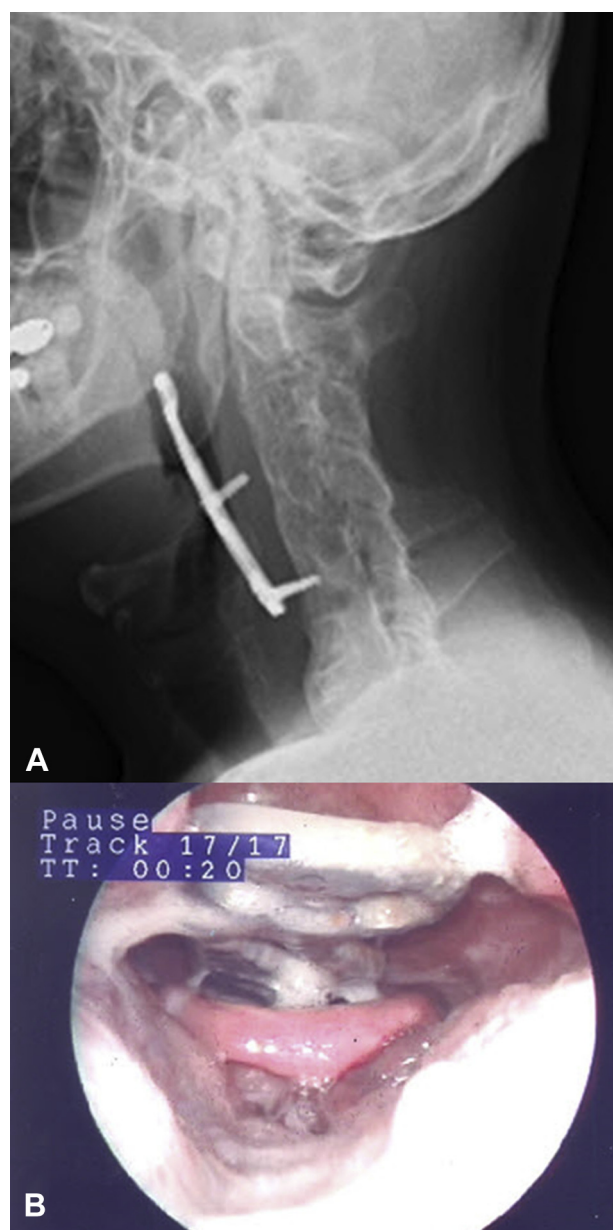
(A) Plain radiograph showing instrument displacement. (B) Pharyngoscopic image showing plate over epiglottis (case no. 4).
